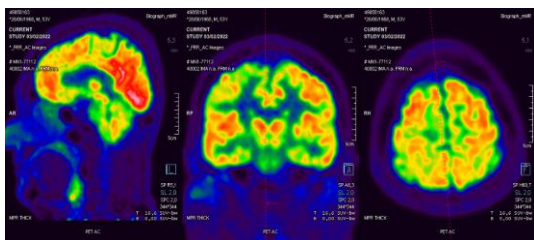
PET/MRI of patient 3. We can observe mild hypometabolism of the medial portion of the right supplementary motor area compared to the contralateral side.
